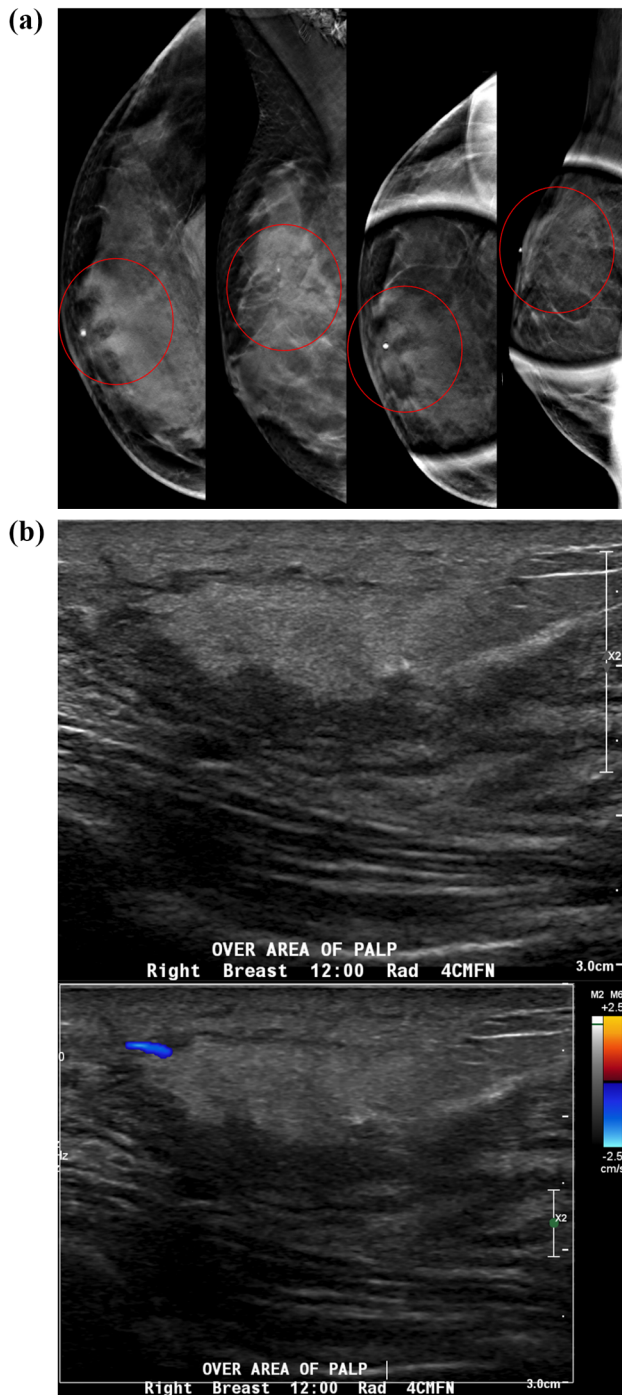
a Diagnostic mammogram of the right breast in craniocaudal (CC) and mediolateral oblique (MLO) views showed an indistinct equal density focal asymmetry (circles) at the 12:00 position, anterior depth. There was probable intralesional fat, best seen on spot compression views. The overlying skin BB marker denoted the area of patient reported palpable concern. b Diagnostic ultrasound of the right breast at 12:00, located 4 cm from the nipple showed an indistinct hyperechoic area with overlying skin thickening measuring up to 5 mm. The lesion demonstrated local replacement of the subcutaneous and anterior preglandular fat, with probable extension into the underlying glandular tissue. There was no significant internal vascularity
